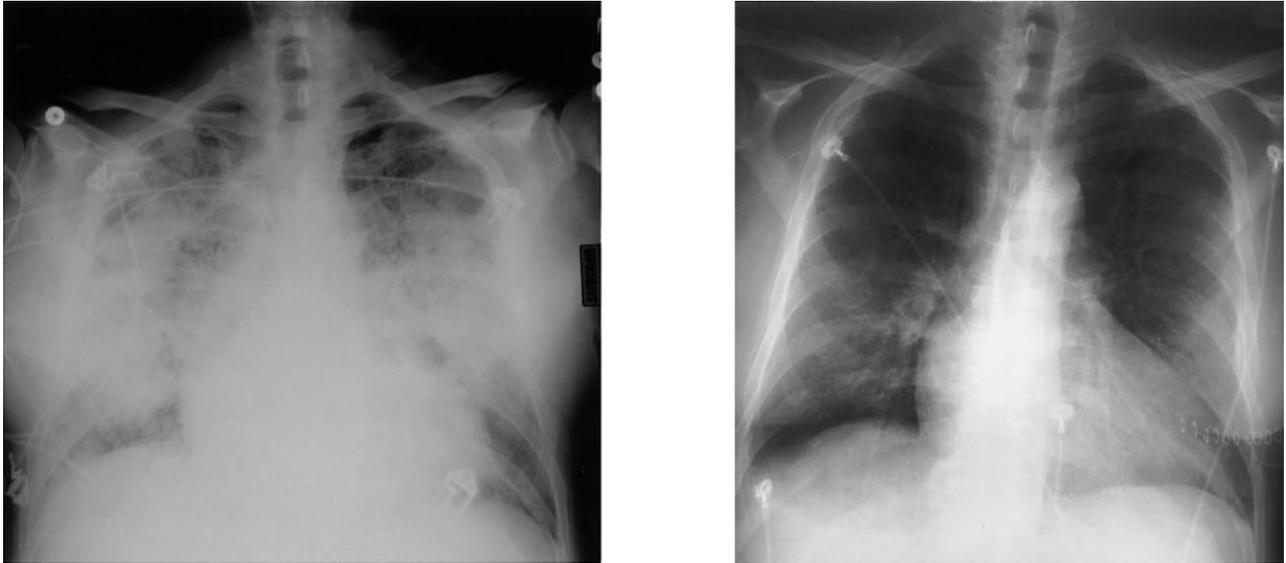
Chest radiographs. Left: At onset of hemoptysis, within 2 weeks from receiving multiple boluses of IV amiodarone. Right: Eleven days after discontinuation of amiodarone and starting corticosteroids, showing clearing of pulmonary infiltrate.
